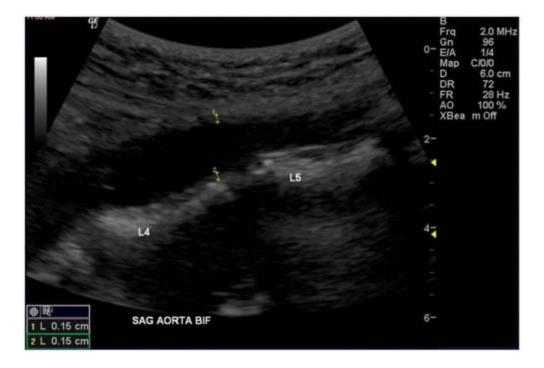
Sonographic measurements taken of the intima-media thickness in the sagittal mid-abdominal aorta.
